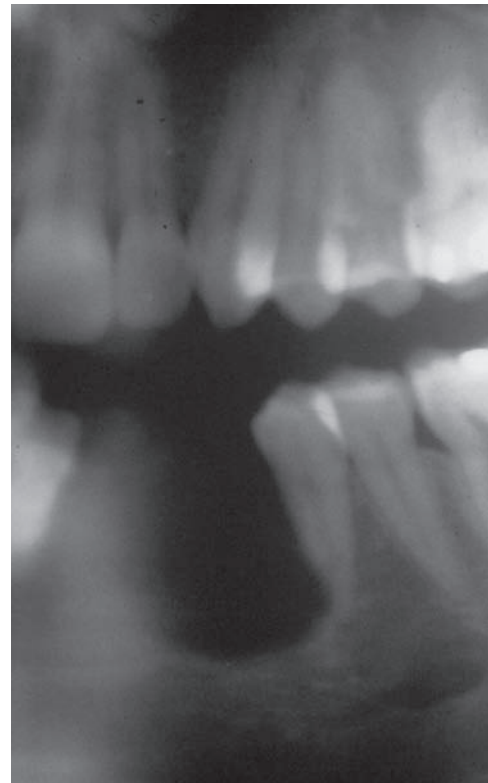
Cortical bone destruction. The central giant cell granuloma (see Chapter 18) pictured in this radiograph has eroded through the cortical bone in the edentulous mandibular area. (Courtesy of the U.S. Department of Veteran's Affairs.)
